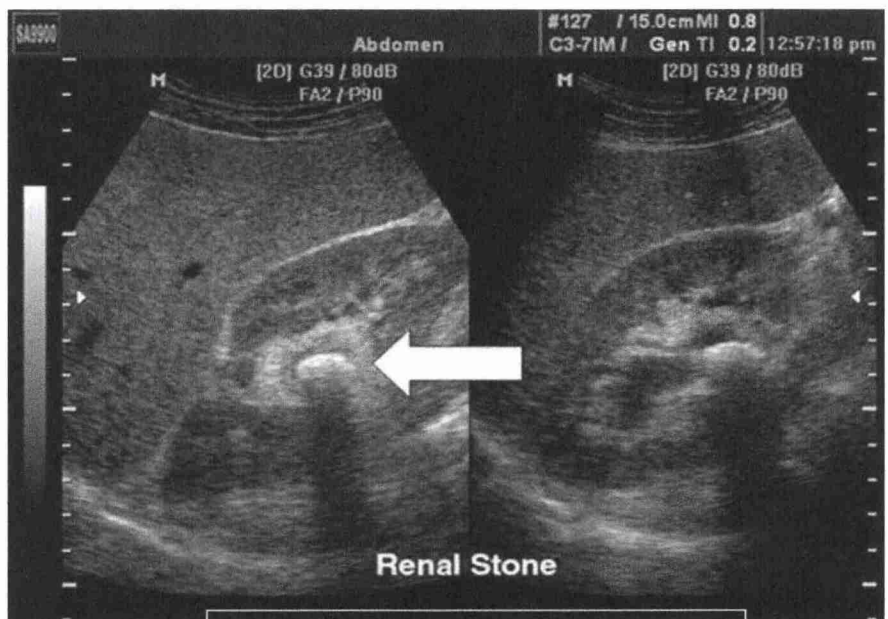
Ultrasound showing stone
